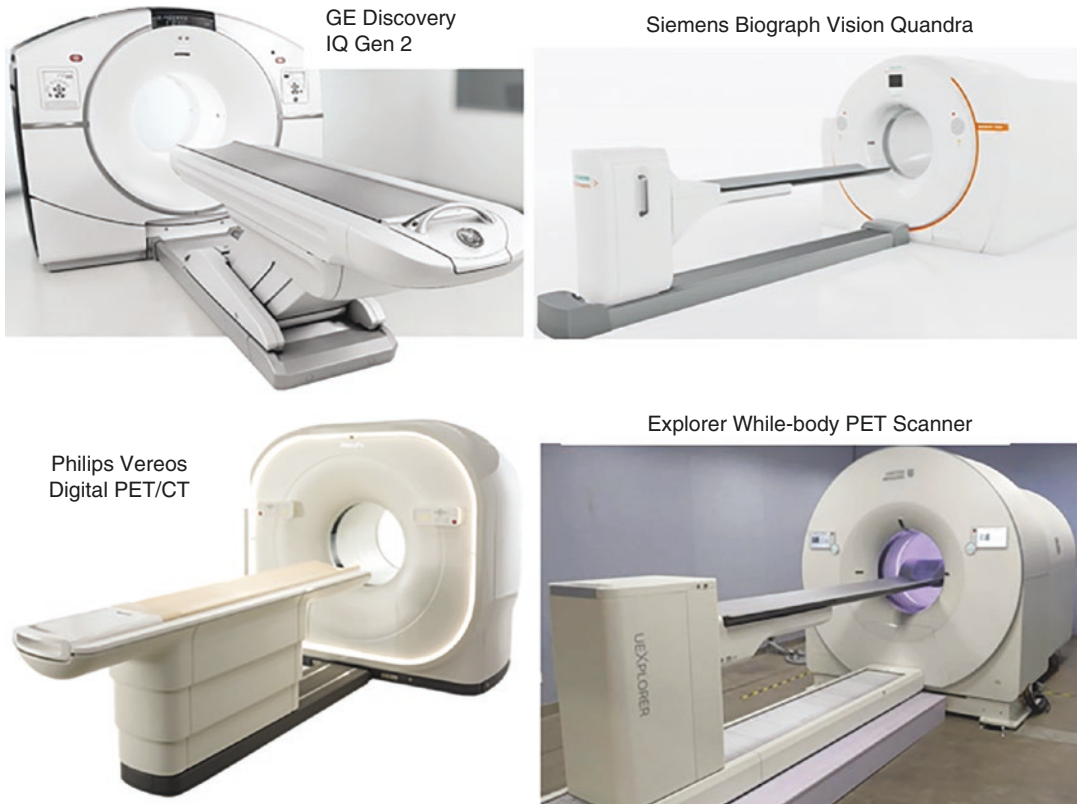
PET/CT scanners: GE Discovery IQ Gen 2 is the next generation of our high-performance PET/CT system with faster scan times, with Motion-Free image clarity. Siemens Biograph Vision Quandra has a large axial PET field of view. To cover dynamically from vertex to
